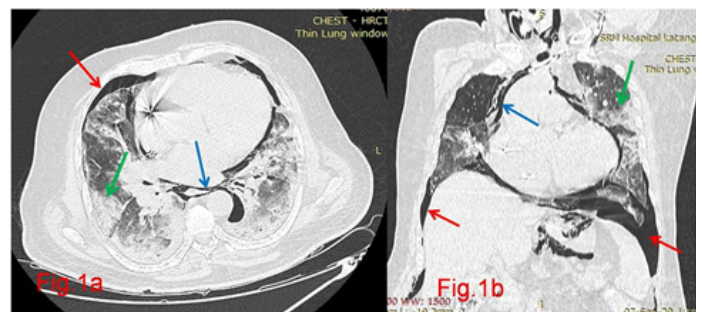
Axial and coronal CT sections shows extensive pneumomediastinum and pneumothorax.
